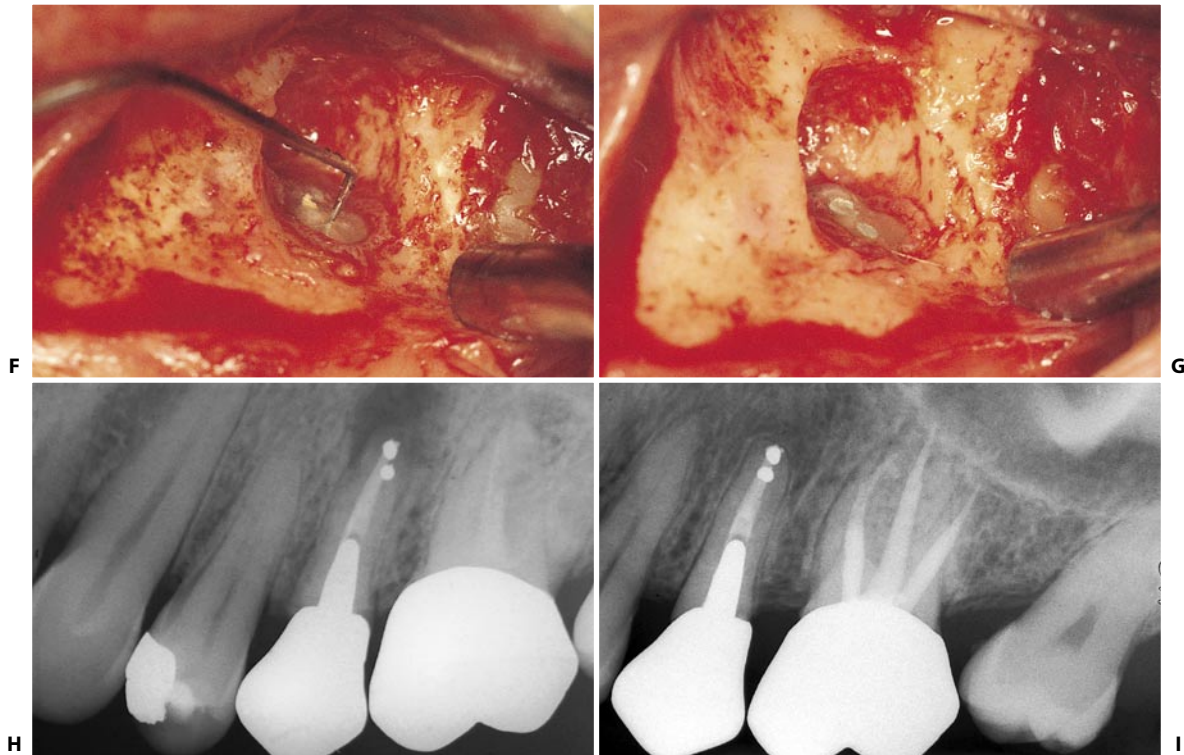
(continued) F. A flap has been raised, the lesion has been excised, and the apex has been bevelled to allow retrofilling. The probe demonstrates the patency of the buccal canal, which had been left partially untreated. G. Two amalgam retrofills have been made. H. Postoperative radiograph. I. Healing after 30 months.
